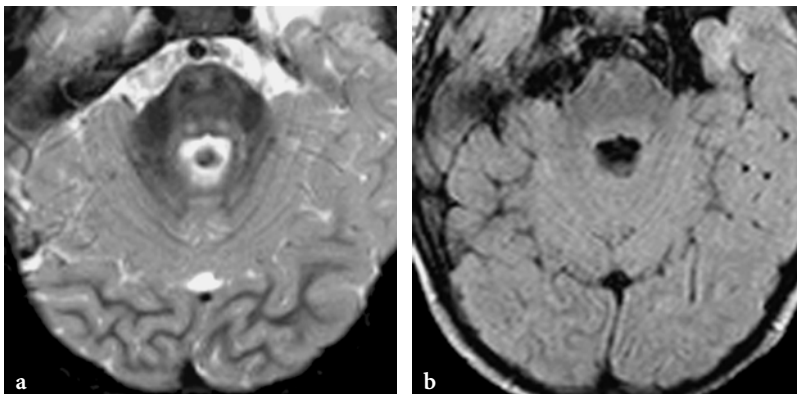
Brainstem abnormalities in a 6-year-old female patient with glutaric aciduria type 1. a The axial modular inversion recovery image shows bilateral, symmetrical signal abnormalities within the central tegmental tracts. Ill-defined faint hyperintensities are also demonstrated within the ventral part of the pons, which clearly outline the unaffected pyramidal tracts, presenting normal hyposignal. b The axial FLAIR image at the same level fails to provide the above information
